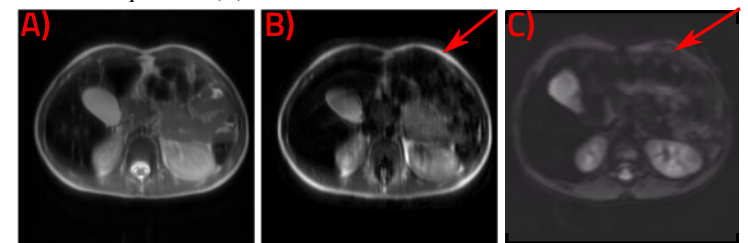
abdominal images A) standard ss-FSE acquisition B) nCPMG ss-FSE $b=500 \text{ s}/\text{mm}^2$ C) Standard clinical DWI EPI acquisition with 8 NEX overscans, $b=500 \text{ s}/\text{mm}^2$
